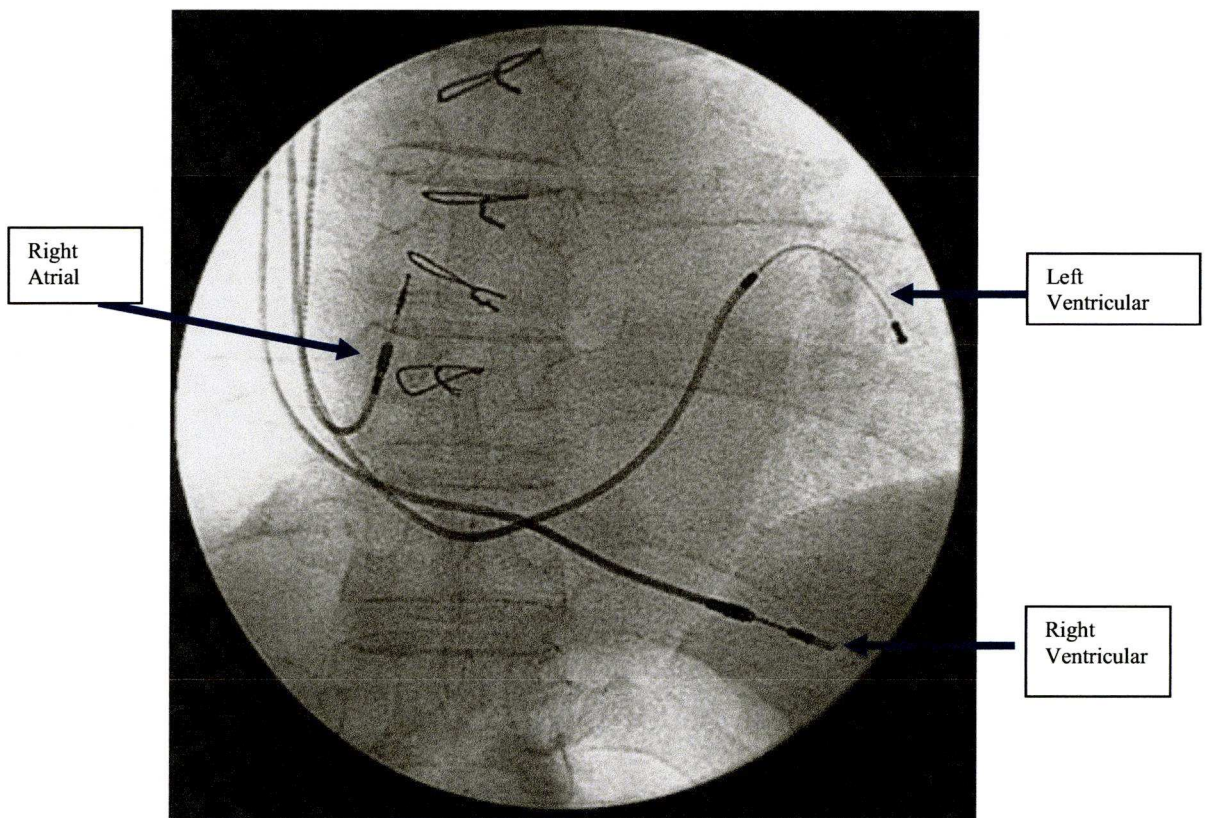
Xray showing lead position in a CRT pacemaker
